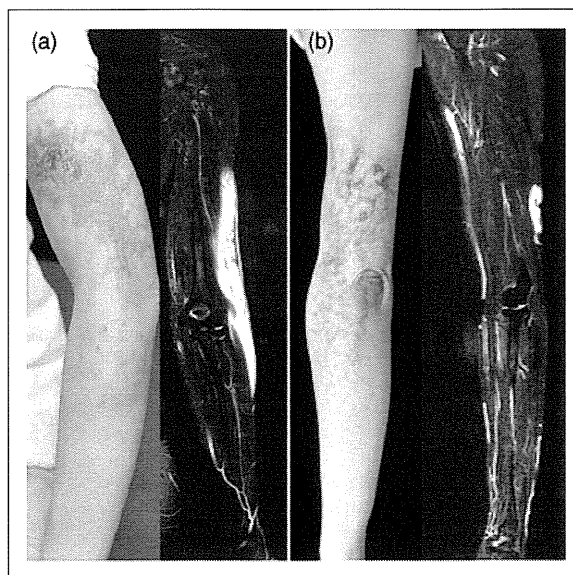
Clinical features and magnetic resonance imaging (MRI) findings of the left arm.
